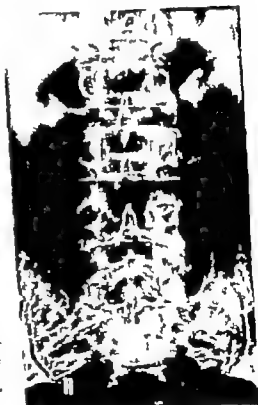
X-ray of the lumbar spine.
